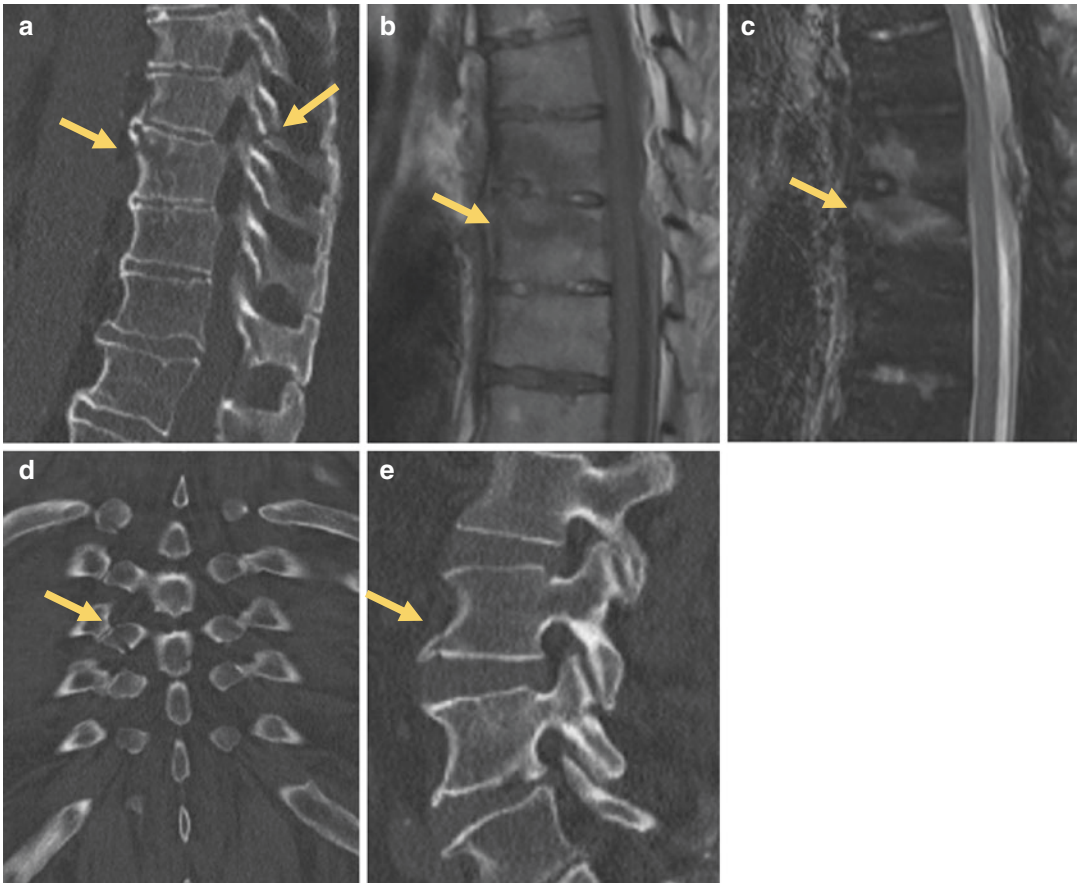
A 52-year-old man with DISH following trauma. Sagittal CT (a), T1-weighted (b), and T2-weighted, fat-saturated MR (c) images demonstrate a transverse fracture through the T9 vertebral body with extension into the posterior elements of T8 (arrows) and a small amount of anterior distraction. The MRI has the added benefit of revealing a small amount of epidural
